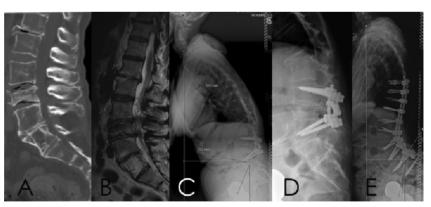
72y female patient with primary low energy fracture in L3 (A) and spinal stenosis (B). Secondary low energy fracture in Th12 and severe loss of sagittal balance (C). Instability of the kyphotic segment and mobility of thoracic spine tested with bending and fulcrum x-rays (D). Stabilization of kyphotic fracture, correction with pedicle subtraction osteotomy in primary upper instrumented level L2 and mounting the long construction to pelvis with iliac screws (E).
